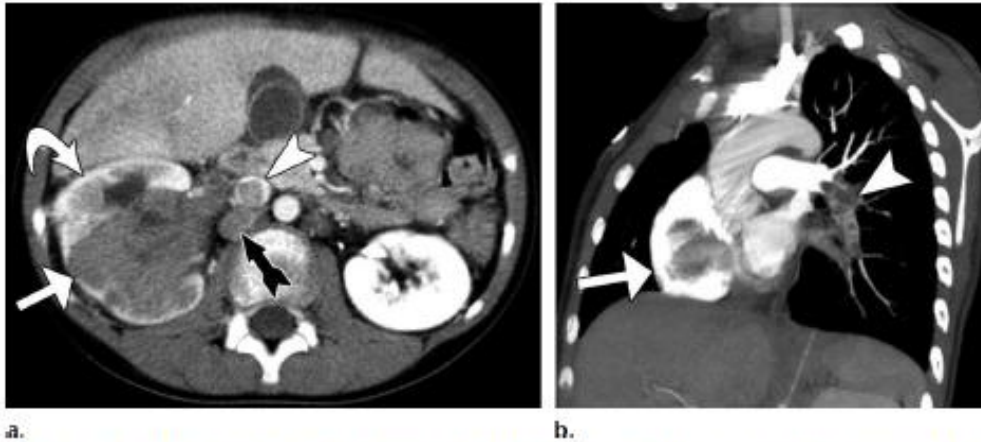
Wilms tumor with rhabdomyomatous differentiation in a 12-year-old boy. (a) Axial postcontrast CT image shows a partially circumscribed slightly heterogeneous tumor (straight white arrow), which is hypoattenuating compared with enhancing renal cortex (curved arrow). Hypoattenuating tumor thrombus surrounded by contrast material is seen in the IVC (arrowhead). Also note the enlarged regional lymph node (black arrow). (b) Oblique sagittal image from pulmonary embolism CT shows hypoattenuating tumor thrombus in the right ventricle (arrow) and left lower lobe pulmonary artery (arrowhead).
